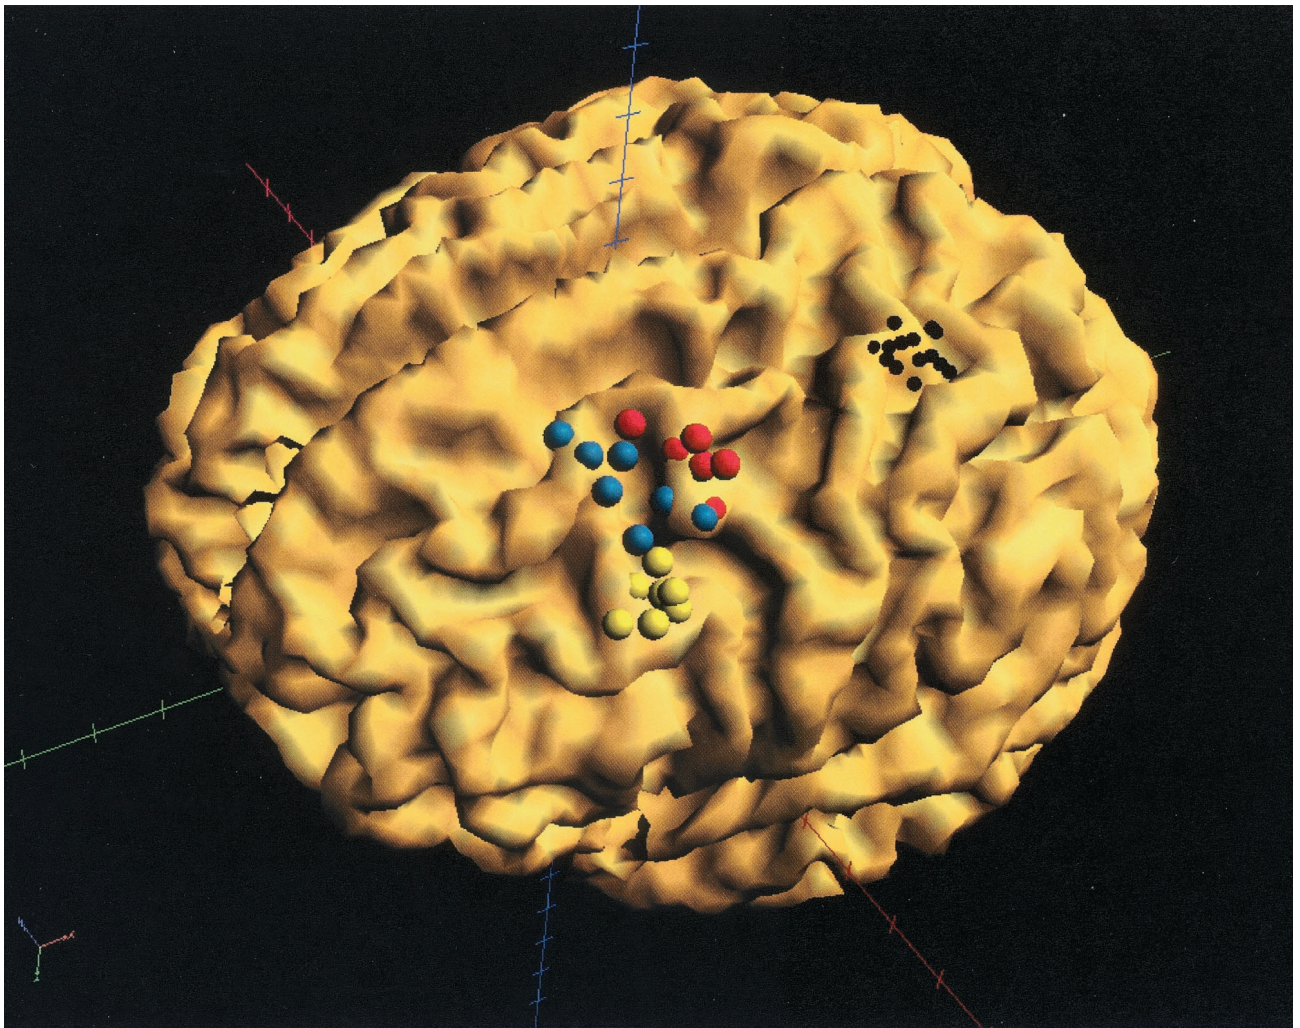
The individual Talairach coordinates before and after standard positioning of the coil are visualized in an individual surface rendered magnetic resonance image of the brain (white matter segmentation) that was transformed into Talairach space (view onto the left frontal cortex). The small black dots indicate the optimal sites for abductor pollicis brevis muscle stimulation over the motor cortex (i.e., the region around the lateral edge of the hand knob). The larger dots indicate the rostral coil positions over the different Brodman areas: red BA 6, blue BA 6/8 and 8, yellow BA 8/9 and 9.
